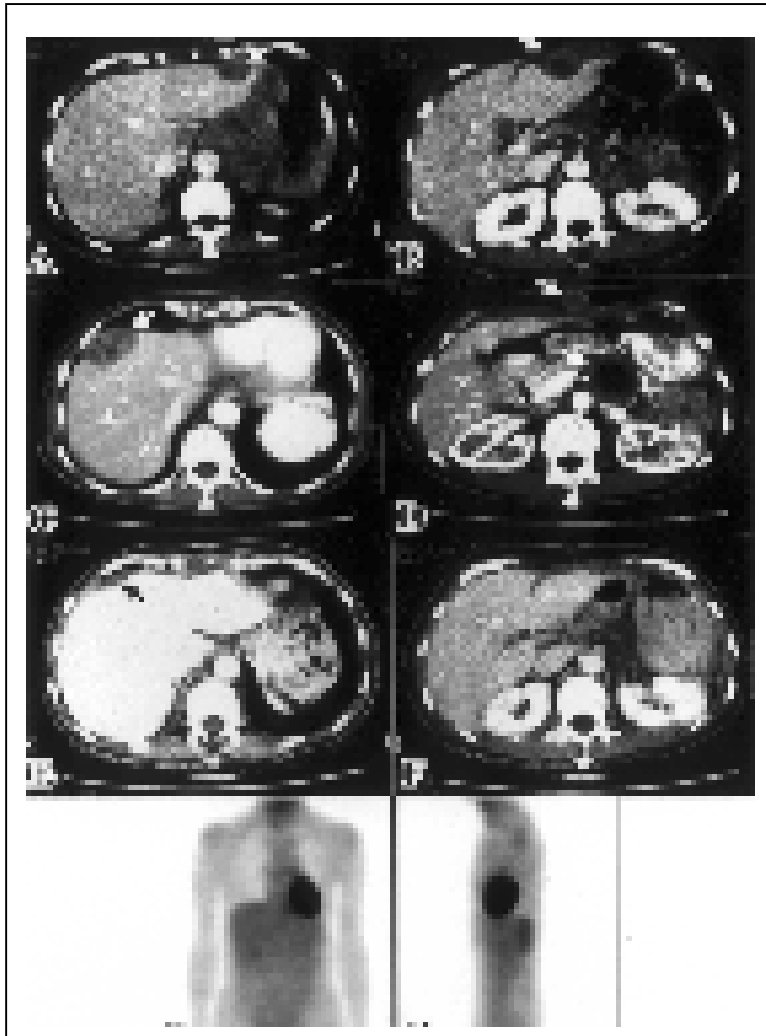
Progressive subcutaneous nodules and abdominal tumor growth and hepatic metastasis (white arrow) after debulking and radiation therapy. (A,B: Jan. 10, 2001, before debulking; and C,D: Mar. 21, 2001, before glivec therapy ) Only hepatic tumor scar (black arrow) visible in the following CT after glivec therapy. (E,F: Jun. 7. 2001) No tumor 18 fluorodeoxyglucose uptake was found in the following 18FDG-PET scan examinations on Apr. 26, 2001 (after 18 days' glivec therapy, Adelaide hospital, not shown) and Jan. 4, 2002 (G,H, Jen-Ai Hospital).
